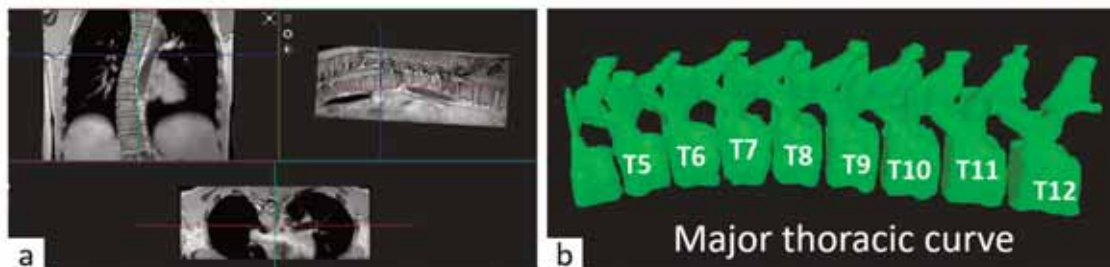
Example of automatic 3D image segmentation of the spine: (a) MRI image of AIS patient and (b) 3D reconstruction of major thoracic curve of the spine generated by the proposed deep-learning algorithm.
